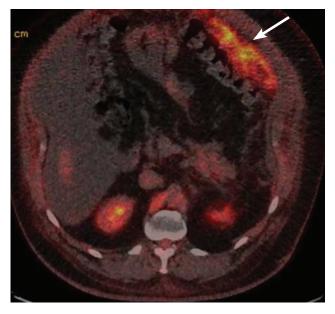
Positron emission tomography/computed tomography performed after therapeutic paracentesis. There is significant hypermetabolic activity along the margin of the greater omentum (arrow) consistent with peritoneal carcinomatosis.
